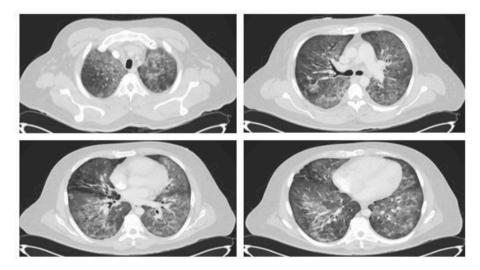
CT scan showing extensive bilateral parenchymal ground glass opacities with peribronchial consolidation.
